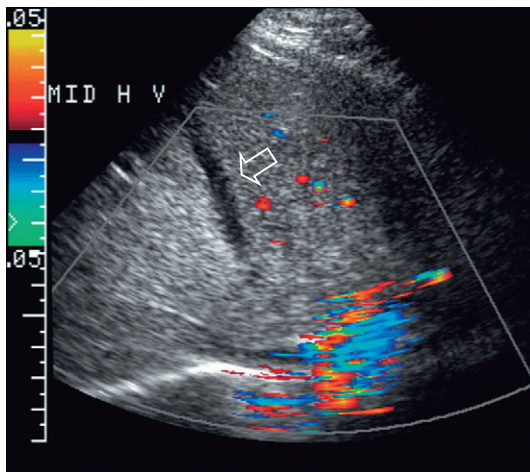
Transverse colour Doppler image of the upper liver. Even with maximised Doppler sensitivity, no flow was perceived in the middle hepatic vein of this patient (arrow). The hepatic vein had become thrombosed when a central line was inadvertently advanced through the heart into the inferior vena cava and up into the middle hepatic vein. This relatively acute thrombus is hypoechoic compared to the surrounding liver parenchyma. As thrombus matures, however, the echogenicity tends to become isoechoic with the adjacent liver and the thrombus becomes harder to perceive.
